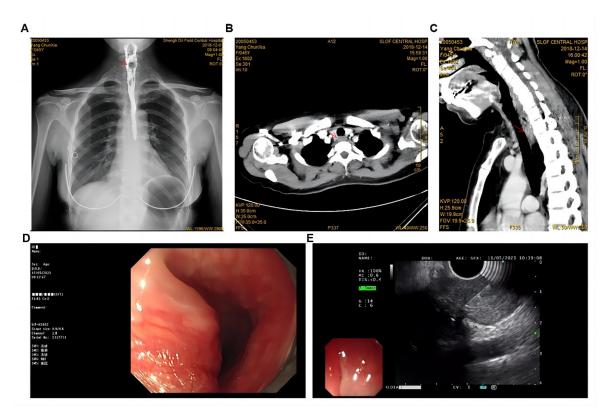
Imaging and endoscopy results. (A) An oval filling defect measuring approximately 2.6×1.8 cm was observed in the cervical segment of the esophagus, characterized by a smooth margin, clear boundary, and soft local wall. There was good dilatation with a slightly obstructed passage of barium (arrow). (B,C) Localized thickening of the right wall of the cervical segment of the esophagus, measuring 2–3 cm, was noted. This thickening exhibited significant enhancement on contrast-enhanced scans compared to the contralateral esophageal wall, with a computed tomography (CT) value ranging from approximately 83 to 106 HU. The plain scan showed unclear findings, along with eccentric narrowing of the esophageal lumen (arrow). (D,E) Elevated lesions were observed below the esophageal inlet, characterized by a mucosal surface less smooth than normal. Ultrasound imaging revealed substantial thickening of the esophageal mucosa, measuring approximately 2 cm in thickness with a clear boundary.
